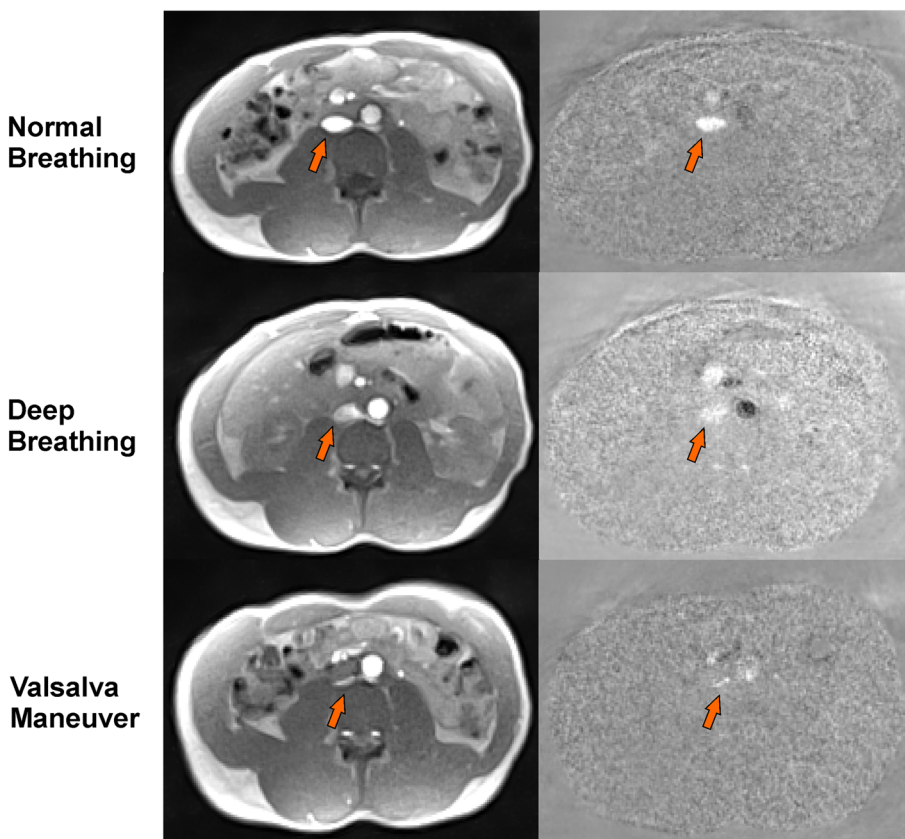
Real-time flow MRI of the infrarenal IVC (arrows) at inspiration (normal and deep breathing) and during Valsalva maneuver. (left) anatomic images and (right) corresponding phase-contrast velocity maps of subject #7 (table 1) selected from real-time flow MRI movies at 50 ms temporal and $1.5 \times 1.5 \times 6.0 \text{ mm}^3$ spatial resolution
